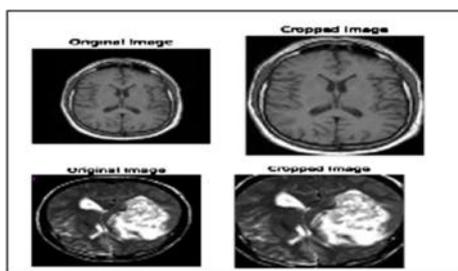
Original and cropped MRI images
